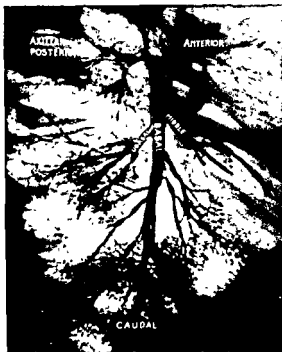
Roentgenogram in transverse position, where the middle lobe branches filled as far as the foliage is evident
